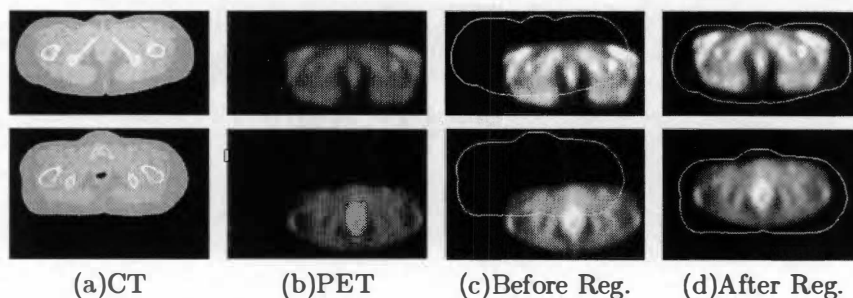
Two pairs of CT/PET images from the third dataset and registration result by the combined mutual information
